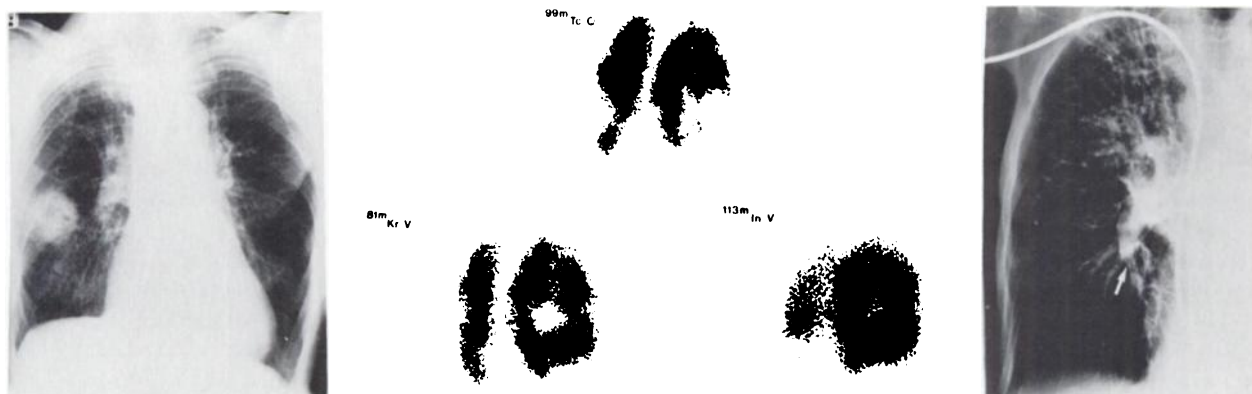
Case 3. Pulmonary embolism, chronic bronchitis, pneumonia. Chest radiograph (left), scintigrams (center), and contrast angiogram (right). Tc-99m perfusion, Kr-81m ventilation, and In-113m aerosol scans are in right posterior oblique views. Chest radiograph shows area of consolidation in right lung. Tc-99m perfusion shows marked underperfusion to consolidated area as well as to areas with normal radiographic appearance. Both Kr-81m and In-113m aerosol scans show that regional ventilation, although abnormal, is still present in most underperfused areas, indicating mixed disease. Collimator penetration results in lower resolution with In-113m relative to Kr-81m in area of decreased activity due to consolidation. Diagnosis of mixed disease [pulmonary embolism (arrow) and parenchymal lung disease] was subsequently confirmed by angiography (right), which shows intravascular emboli on right side (arrow) and peripheral inhomogeneities.
